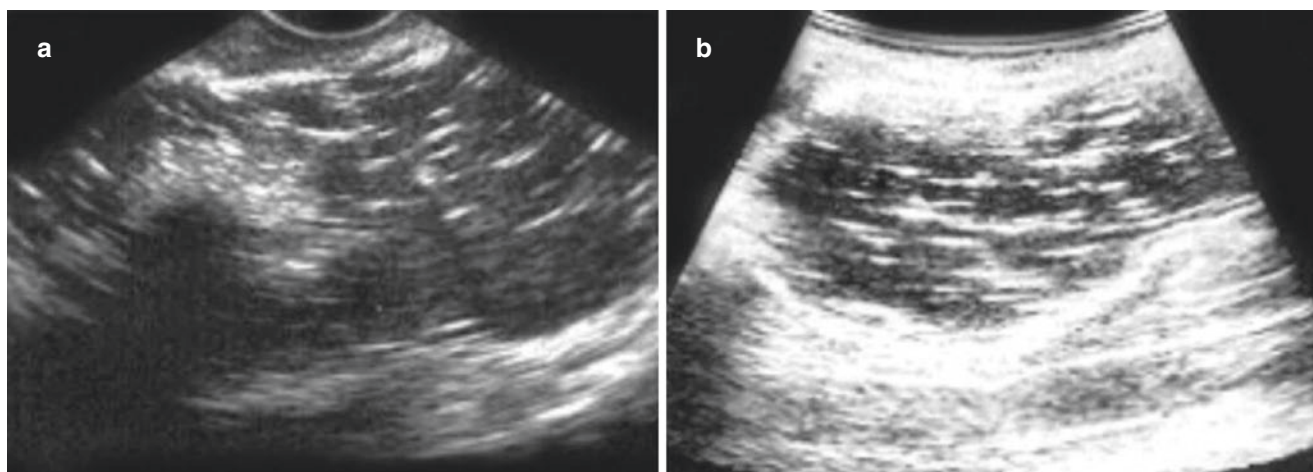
Ovarian teratoma (II). (a, b) Ultrasonography shows cystic mass, with sporadic or multiple hyperechoic lines floating inside, like “starflower”
